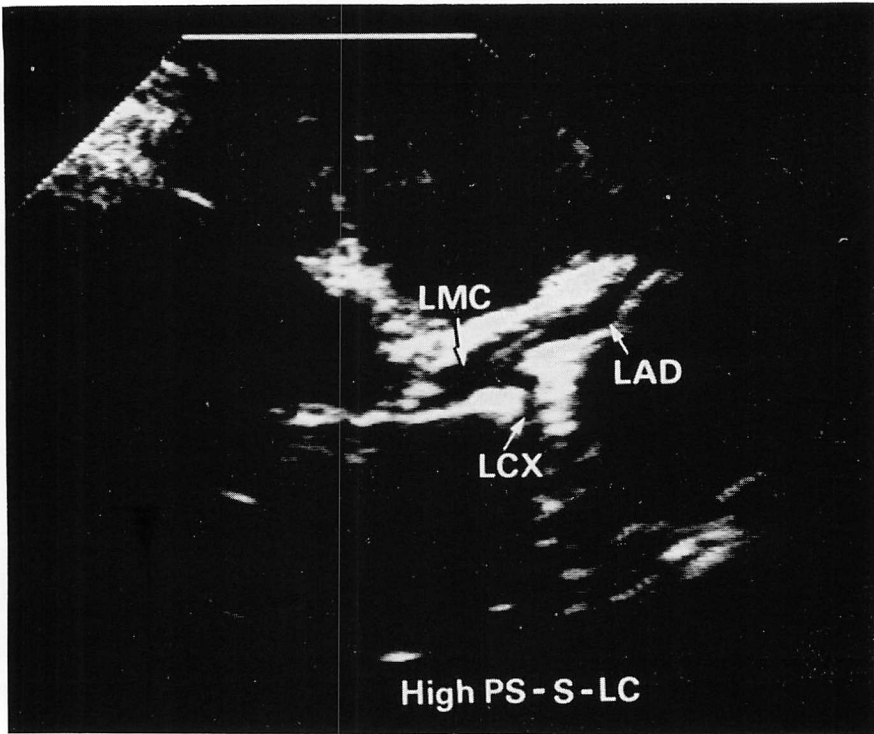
Representative echogram of the LCX recorded by high-parasternal approach and the corresponding coronary arteriogram.
